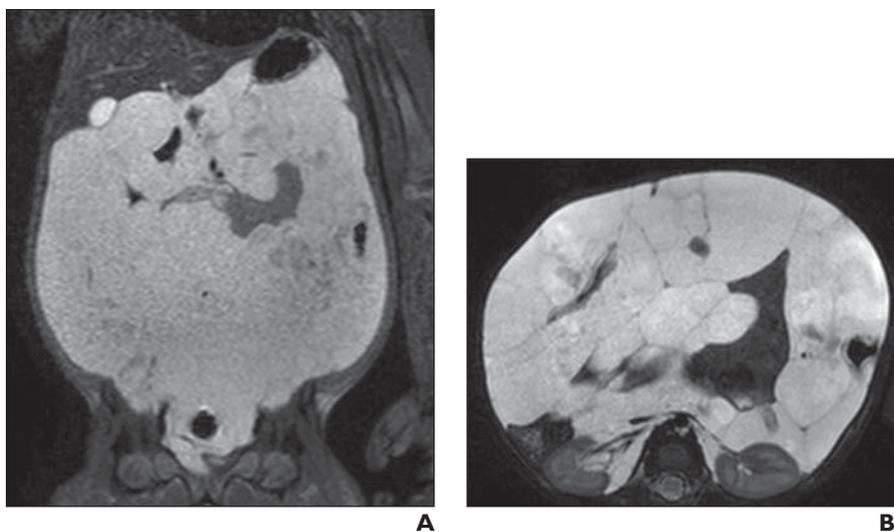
15-month-old boy with abdominal swelling. A and B, Coronal (A) and axial (B) T2-weighted fat-saturated MR images show extensive hyperintense multiseptated mass with mass effect on liver, bowel, and kidneys, consistent with mesenteric and retroperitoneal lymphatic malformation.
